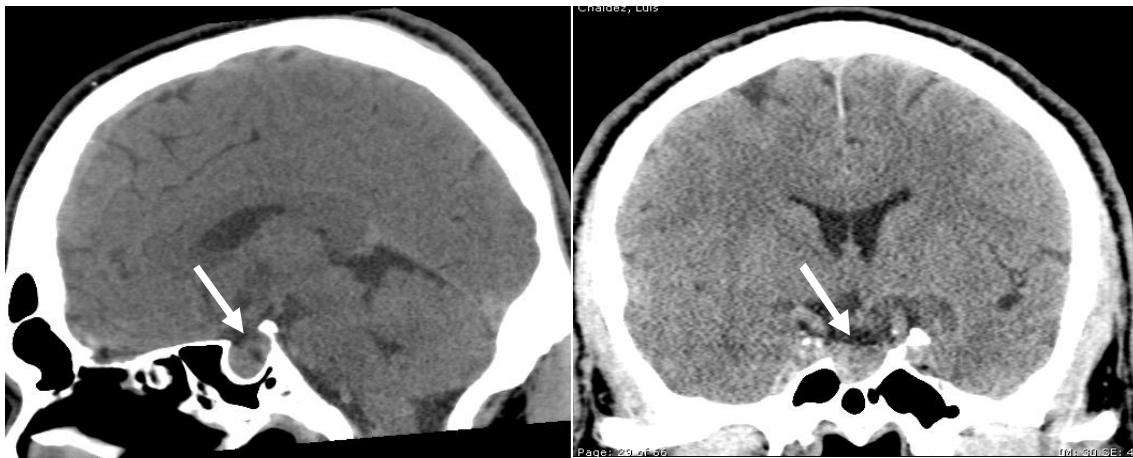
CT brain sagittal and coronal images demonstrating wide sella with enlarged pituitary (white arrows).
